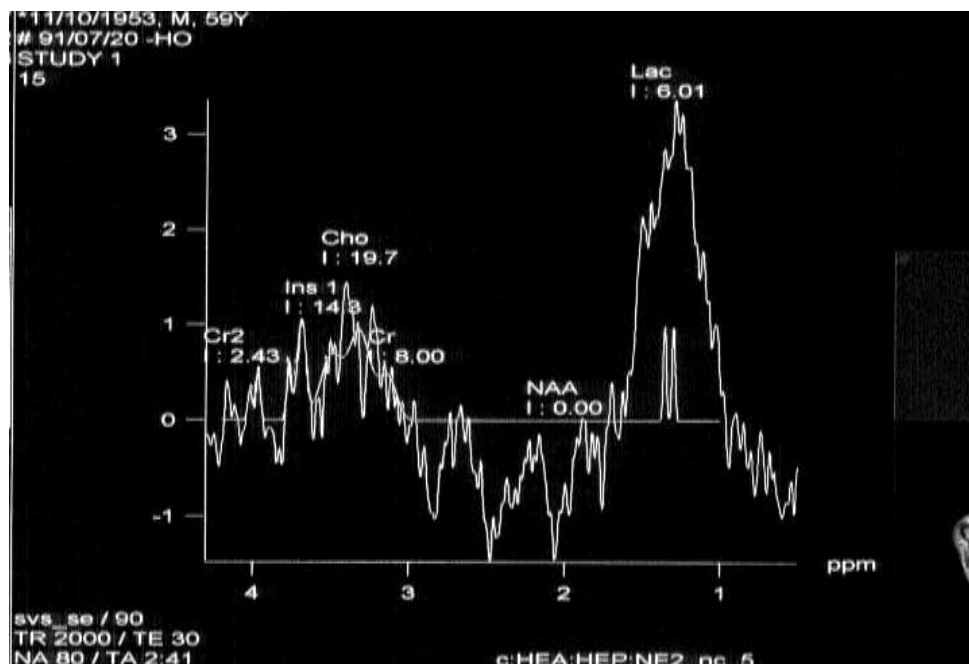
Magnetic resonance imaging (MRS) of right toe
